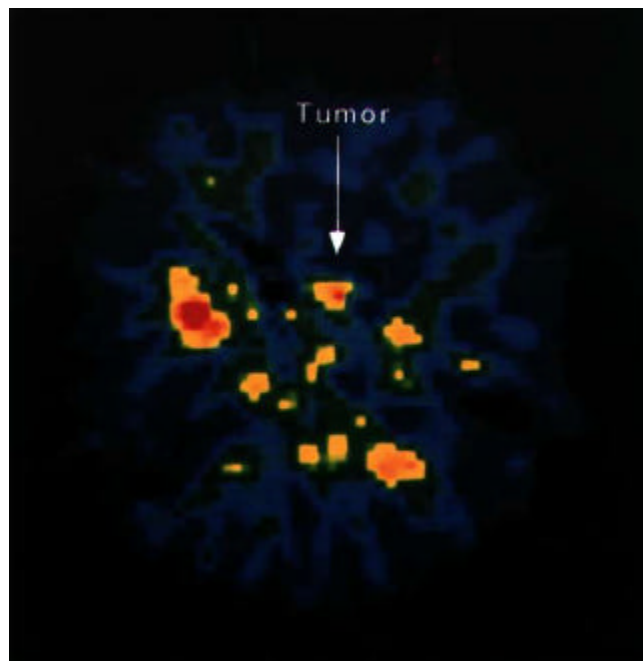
¹⁸F-FDG PET image of case 2. (arrow: pituitary adenoma)
